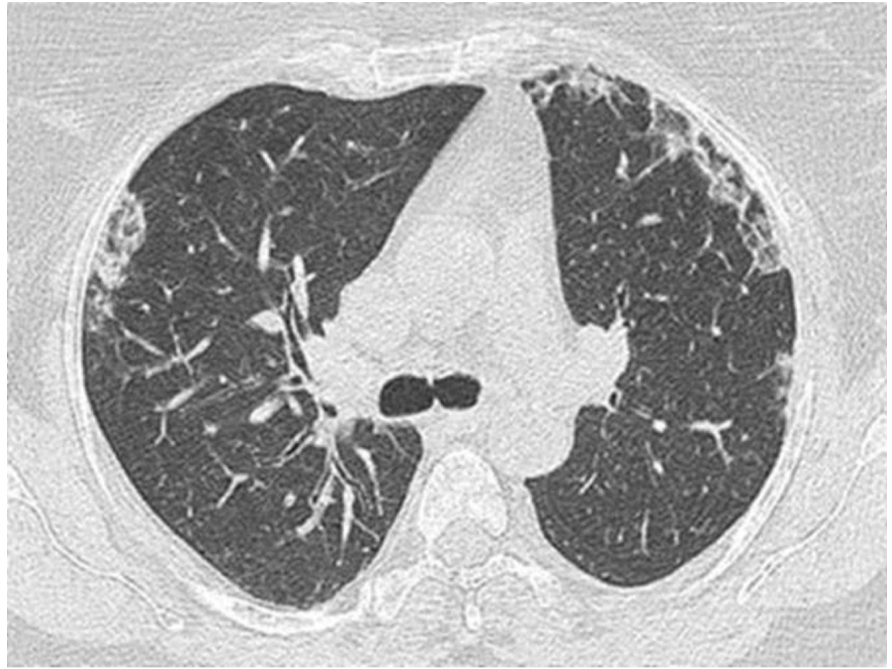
High-resolution computed tomography.
